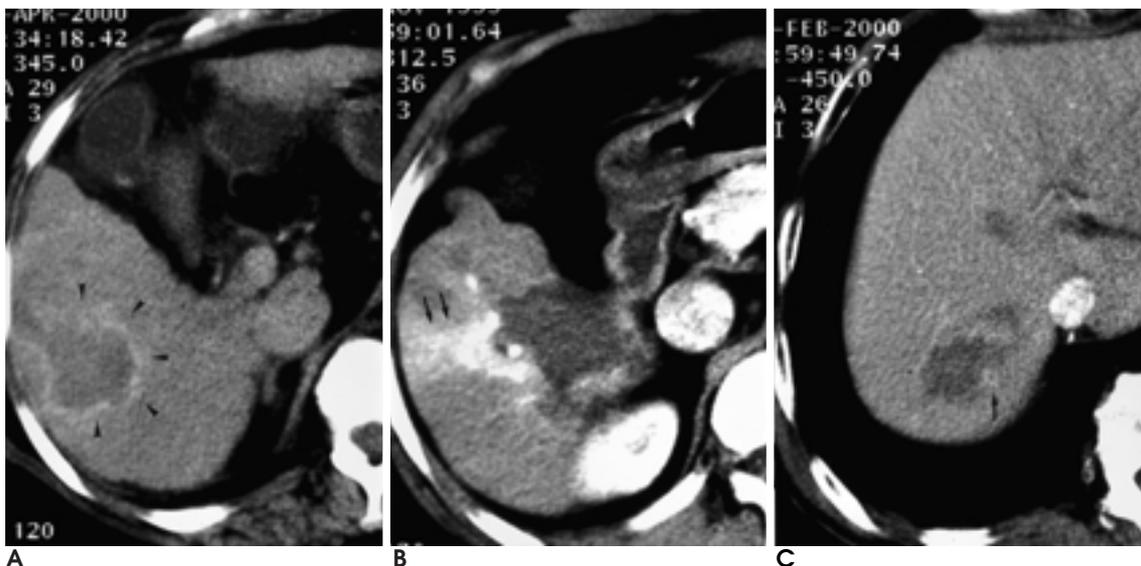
Morphological characteristics of peritumoral hyperemia on immediate follow-up CT.
